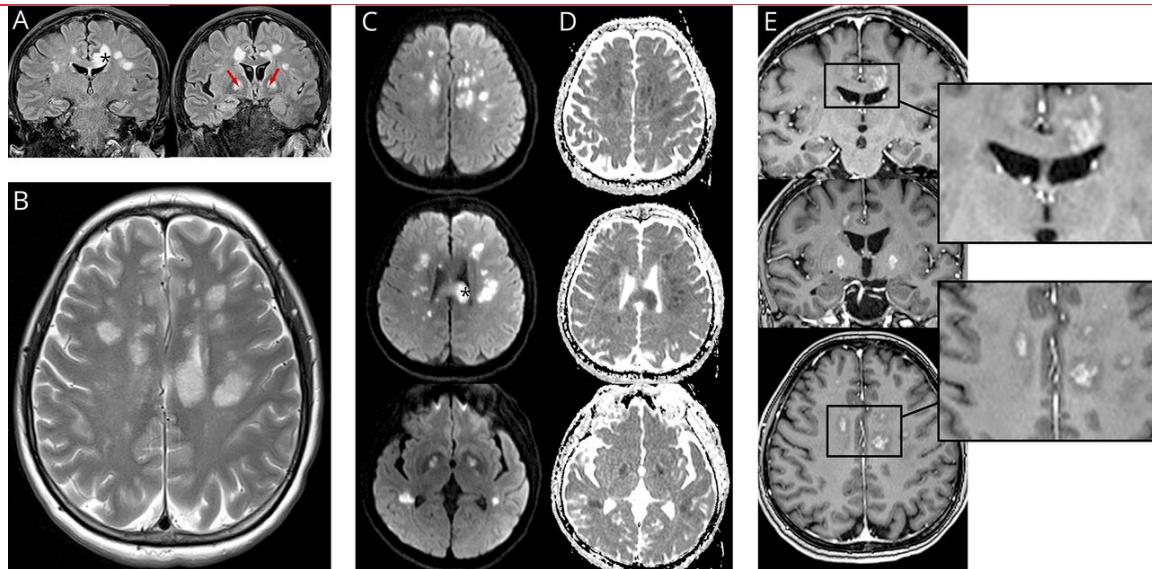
Brain MRI of SARS-CoV-2-related lesions. Multiple supratentorial punctiform and tumefactive lesions involving the white matter bilaterally and showing hypersignal on coronal fluid attenuation and inversion recovery (FLAIR; A), axial T2-weighted images (B), and diffusion-weighted imaging (C) with low apparent diffusion coefficient (ADC; D). Some lesions are periventricular or involve the corpus callosum with a mass effect on the left lateral ventricle (*). Note the restricted diffusion with hyperintensity on FLAIR images within the globus pallidum bilaterally (black arrows). On a follow-up brain MRI, the lesions demonstrate avid enhancement on postgadolinium coronal and axial T1-weighted images (E).
